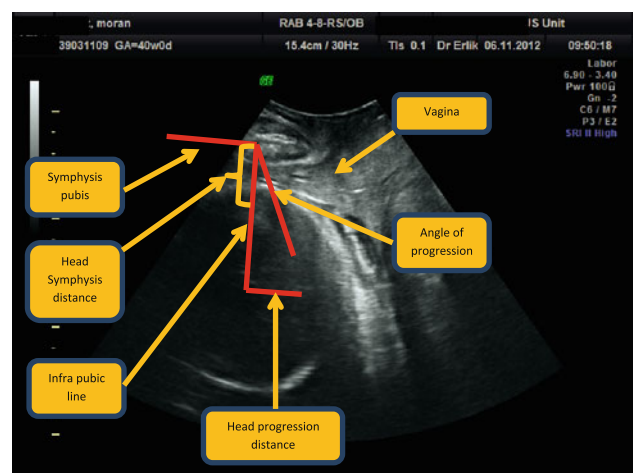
Mid sagittal transperineal ultrasound measurements
